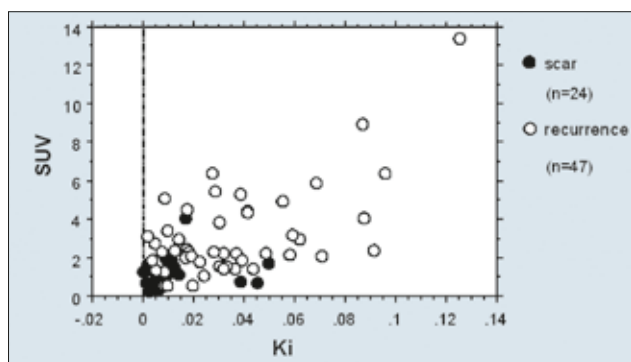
The relationship between Ki and SUV in postoperative lesions (n=71). The data demonstrate an overlap between recurrent and scar lesions in the low Ki and SUV area.
